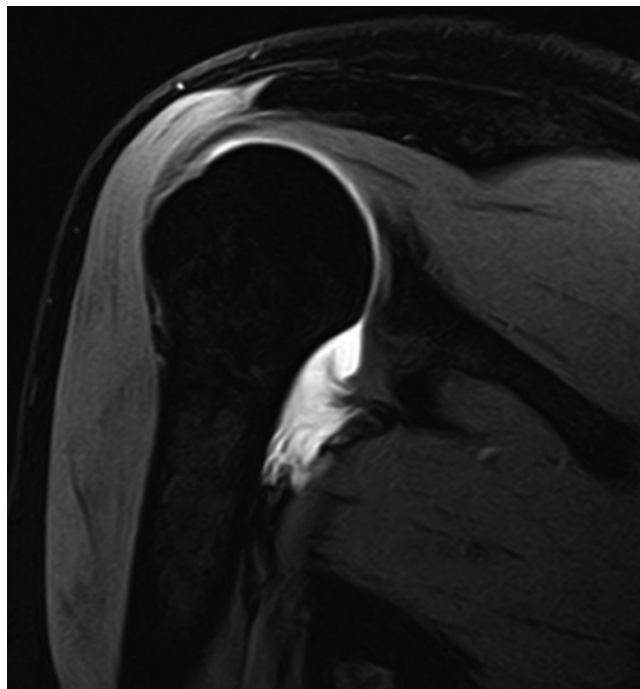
HAGL lesion in MRI arthrography
